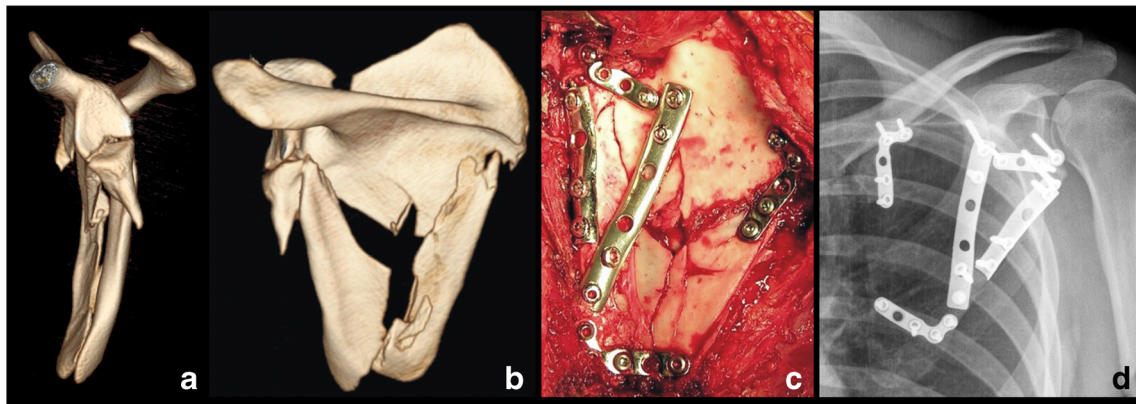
Inferior glenoid fractures and three-part infraspinous fracture of scapular body (female, 18 year old). a + b – 3D CT reconstructions after injury; c – intraoperative view after internal fixation; d – radiograph nine years post-operatively, the radiologic and functional results are excellent
